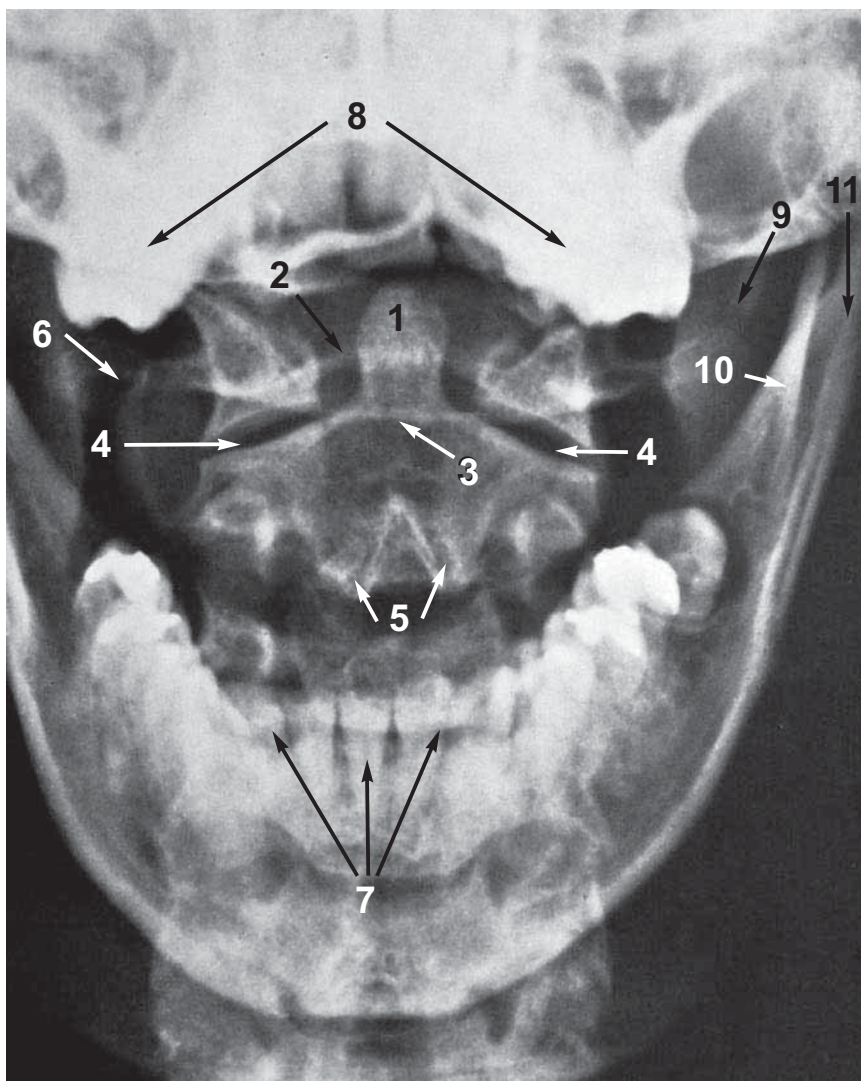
Radiograph of the Odontoid Process and the Atlantoaxial Joints
